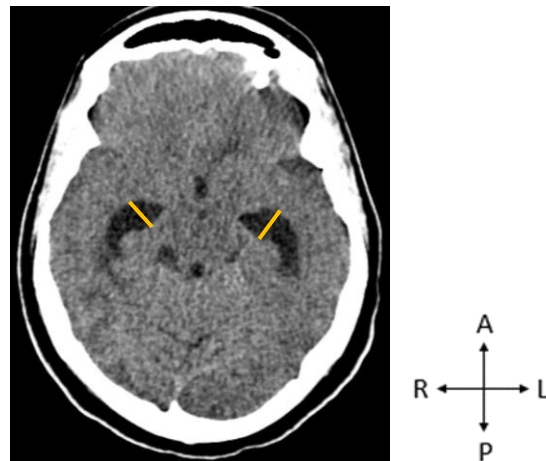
A CT scan of the brain in the axial view showing the temporal horn width, indicated by the orange lines. Image taken from the GSH PACS (20 October 2023). A - Anterior, R - Right, P - Posterior, L - Left.
